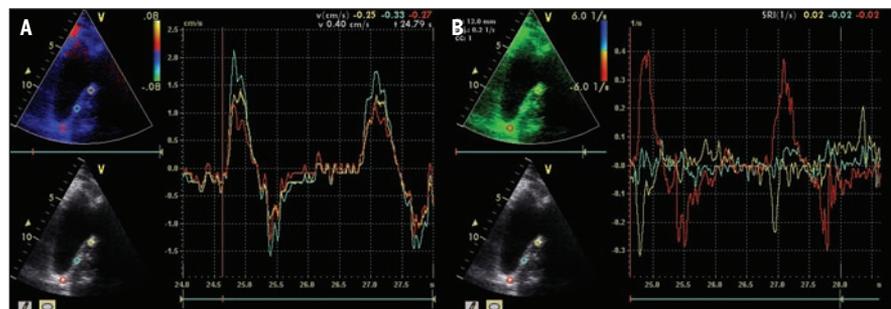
(A) Tissue velocity imaging. In the bottom left of the figure is a grayscale brightness mode ultrasound image of the bladder base during subsequent pelvic floor contractions. It is used to navigate and localize 3 measuring points (red, green, and yellow circles). Above this is the same image with tissue velocity analyzed via colour Doppler for the 3 sites. By plotting the velocity (cm/s) of the sites (x-axis) against time (y-axis), it can be determined that in this example there is no difference in velocity between the points. Scanner: Vivid 7, GE-Vingmed Ultrasound, Horten, Norway. Note the bladder is sparingly filled to better demonstrate displacement. (B) Strain rate imaging. Strain rate analyses (the rate by which strain occurs) of the same data involve plotting the strain rate period (1/s) against time (s). In this example strain rate differs at the 3 sites. The tissue marked by the yellow point has a negative strain rate, indicating that the tissue is compressed at the beginning of the contraction. The tissue marked by the red point initially exhibits a positive strain rate, indicating elongation; it then exhibits a negative strain rate indicating compression. The tissue marked by the green point undergoes mild compression and elongation (Scanner: Vivid 7, GE-Vingmed Ultrasound, Horten, Norway).
